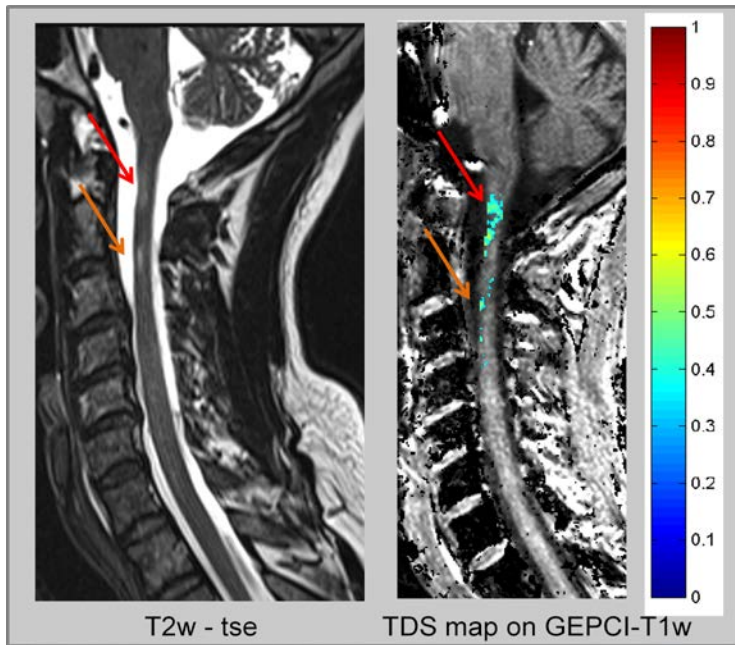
Images of an MS patient. Standard T2-weighted image is shown on the left; GEPCI score map is shown on the right.
